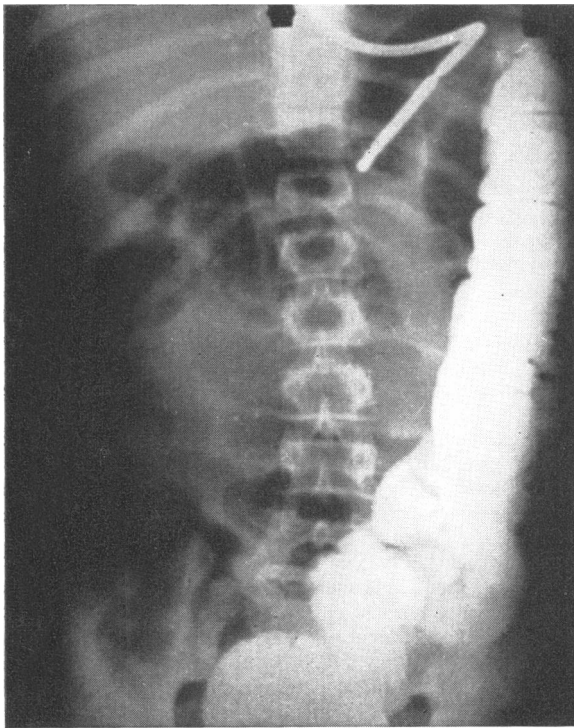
Antero-posterior x-ray after barium enema. Note left-sided colon.
